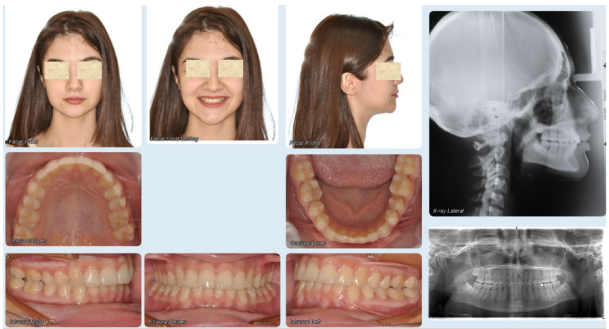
Extraoral and intraoral photographs, panoramic radiograph, and lateral cephalogram at the 4-year 9-month follow-up, demonstrating long-term stability of the treatment results.
